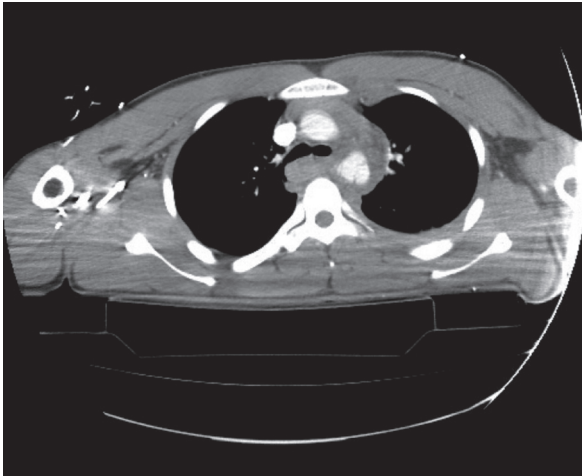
Pre-operative CT angiography of a 53 years old male (G.S.), which shows the rupture of the aortic isthmus and a mediastinal haemorrhage.
